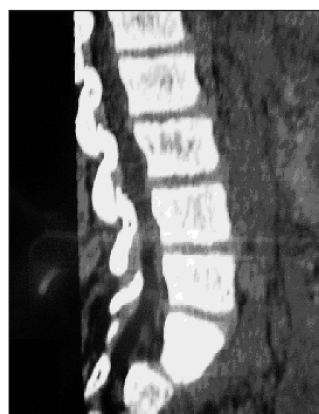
CT lumbosacral region lipoma revealing defect of the lamina and intraspinal lipom
